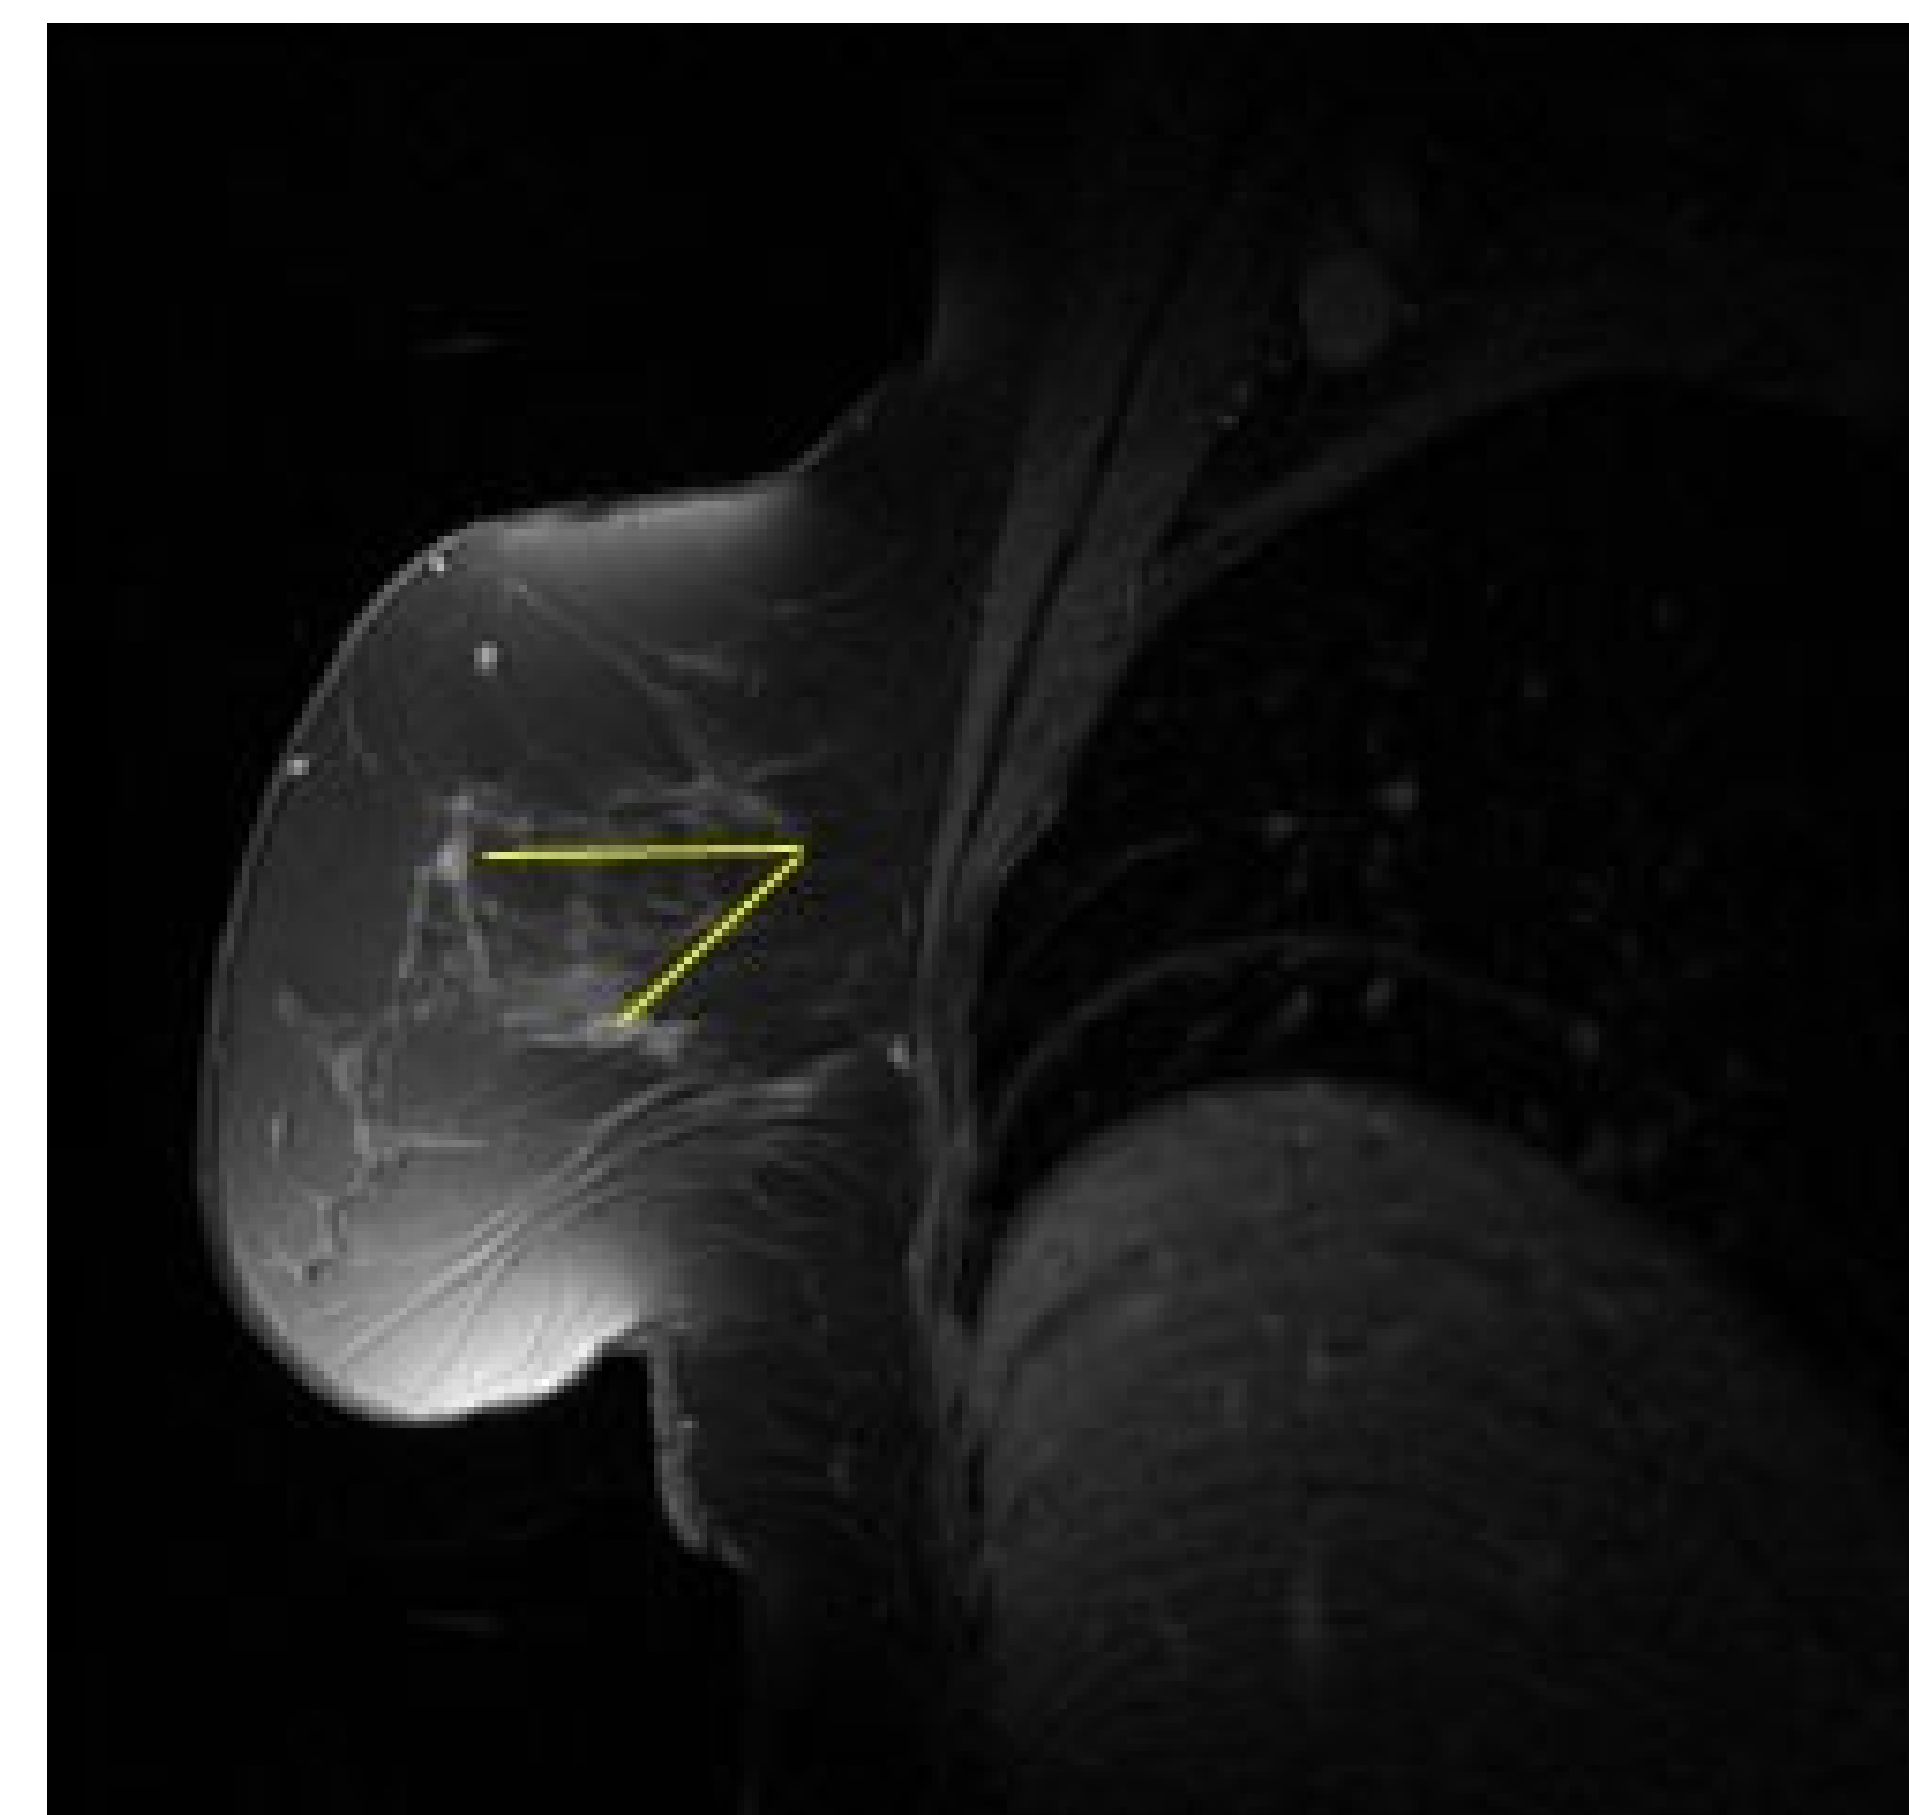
Incidental invasive lesion identified by MRI on the same sagittal slice as the initial cancer
